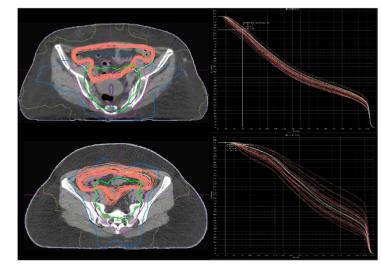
Central axial CT slice of two patients where the inter-fractional variation in the position and shape of small bowel is shown against the isodose lines. The corresponding DVHs are also shown (green is the planned DVH, orange are the fractional DVHs).
